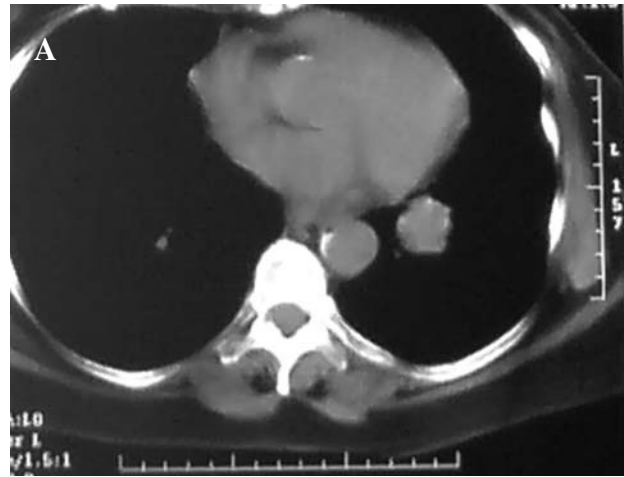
Single pulmonary metastasis in a patient operated for carcinoma of the breast. Computed tomography shows its localization in the left lower lobe (A) and positron emission tomography confirms the suspicion (B).
